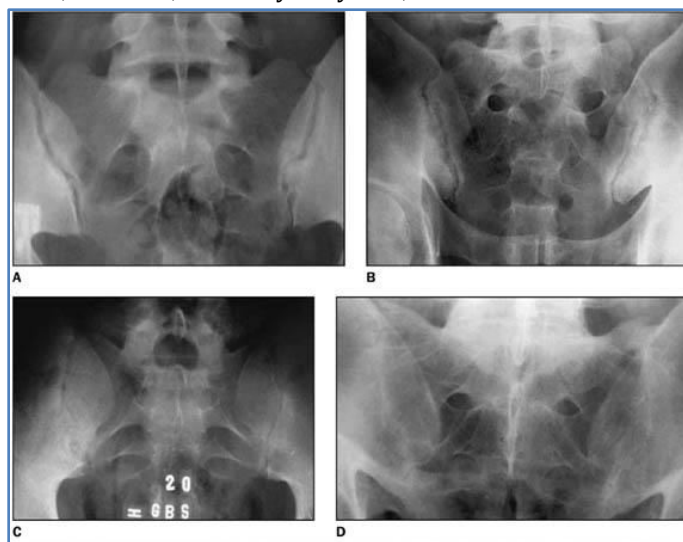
Radiographic changes in sacroiliac joint in AxSpA. A: Grade I = suspicious, B: Grade II = evidence of erosion and sclerosis, C: Grade III = erosions, sclerosis, and early ankylosis; and D: Grade IV = total ankylosis(21).
